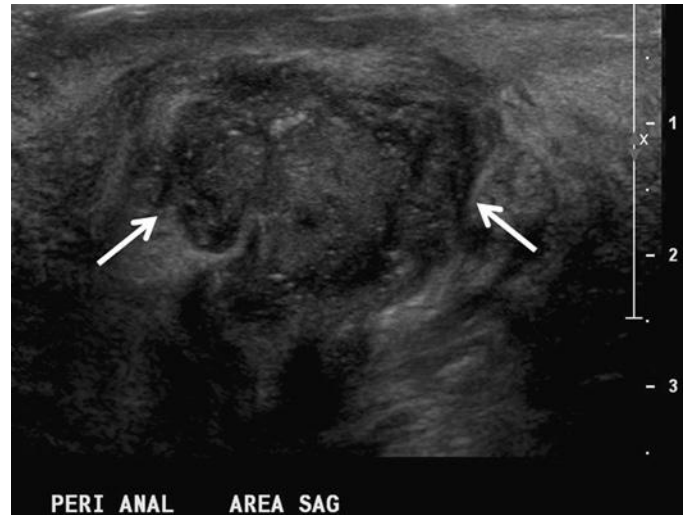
Abscess. Sagittal ultrasound image of the ischioanal fat demonstrates a complex fluid collection (arrows) consistent with perianal abscess.
